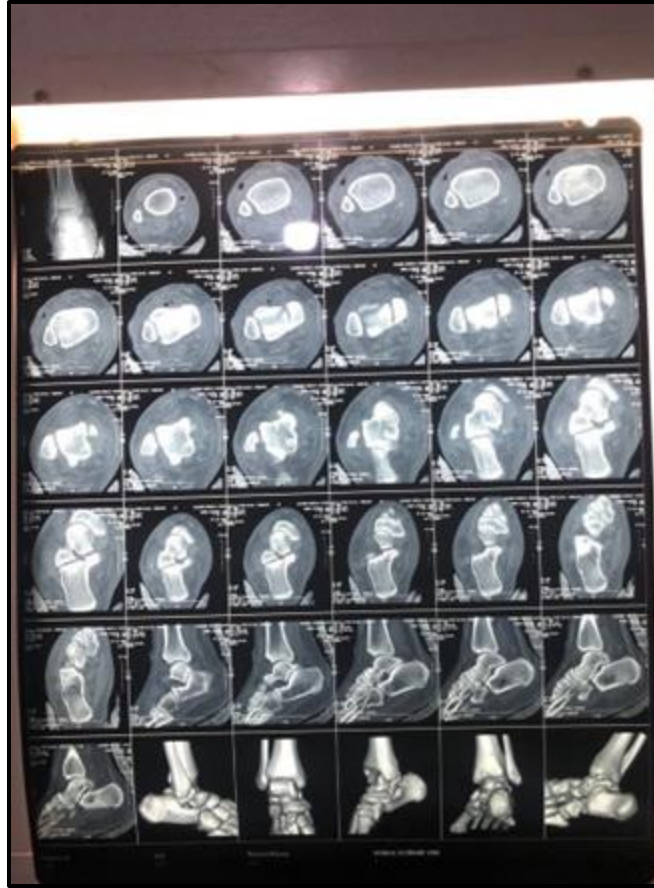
CT scan of right ankle joint showing normal ankle joint, articular surface, Tibial Plafond, talus, calcaneus, distal fibula and no loose body.
